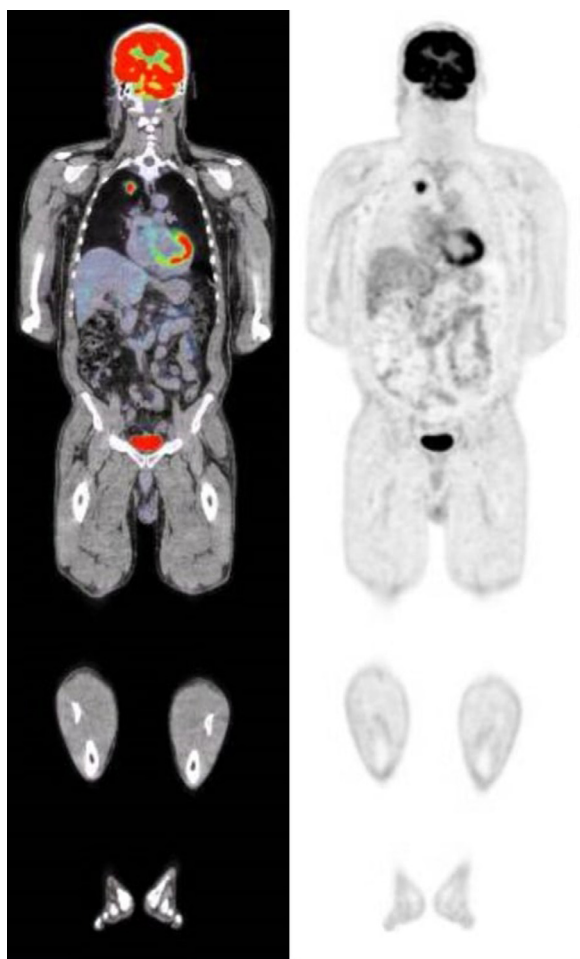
Positron emission tomography–computed tomography disclosed a 2.5-cm-sized right apical lung nodular lesion.
